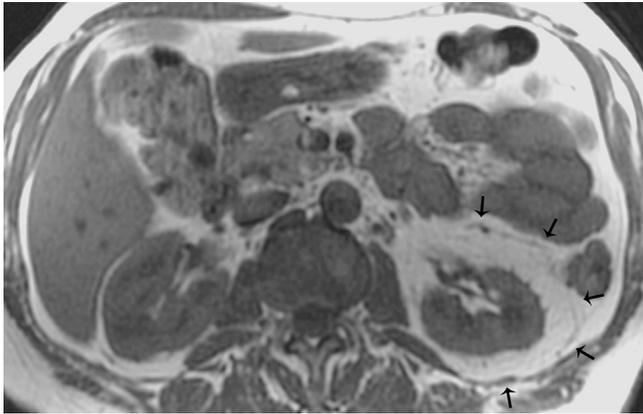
Axial T1-weighted fast spin-echo image shows the anterior, lateral, and posterior renal fascia (arrows) representing the borders of the perirenal space.
